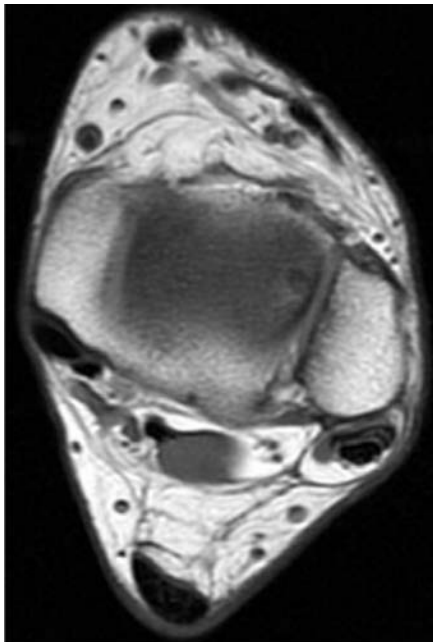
Peroneal brevis tear, T1-weighted image.
